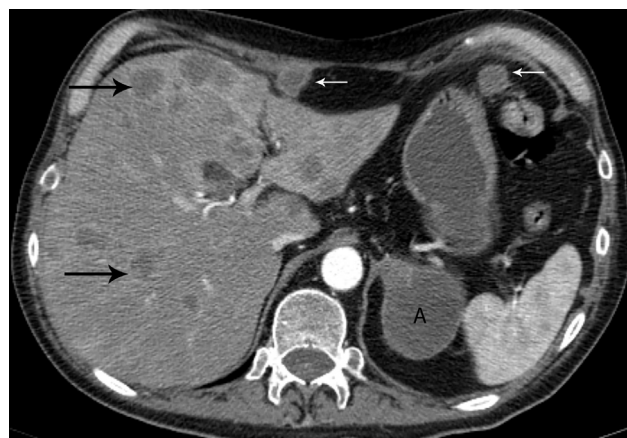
A 58-year-old man with M1c disease. Contrast-enhanced CT shows multiple metastases in the liver (black arrows), peritoneum (white arrows) and left adrenal (A). M1c disease, multiple extrathoracic metastases, constitutes stage IVB. CT, computed tomography.
